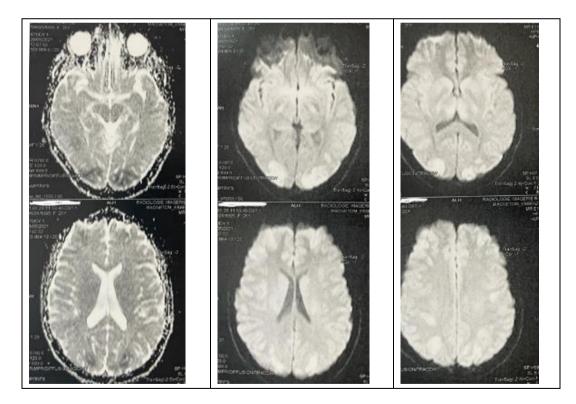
Sequences of MRI brain show the presence of bilateral and symmetric cortico-subcortical occipital and posterior fronto-parietal signal abnormalities. These lesions demonstrate isosignal on T1-weighted images and hypersignal on T2 and T2 FLAIR sequences. They exhibit hypersignal on diffusion-weighted imaging with a restricted apparent diffusion coefficient (ADC), suggesting restricted diffusion. These findings are consistent with bilateral supra-tentorial fronto-temporo-parietal lesions indicative of Posterior Reversible Encephalopathy Syndrome (PRES)
